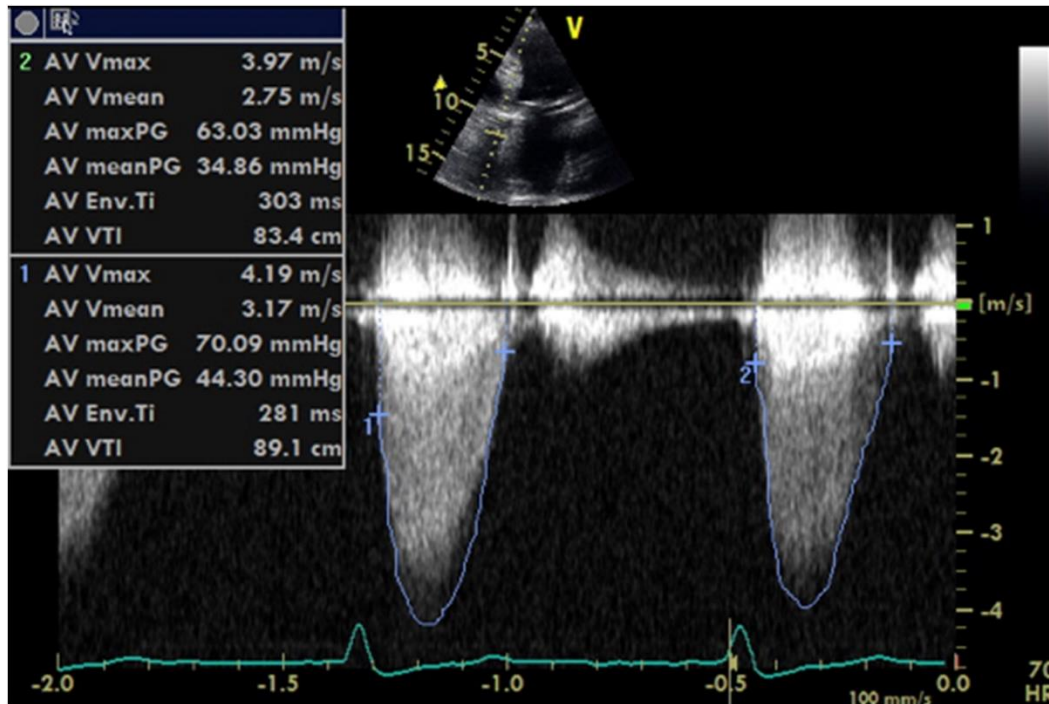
Example of aortic valve assessment using Doppler echocardiography³³
